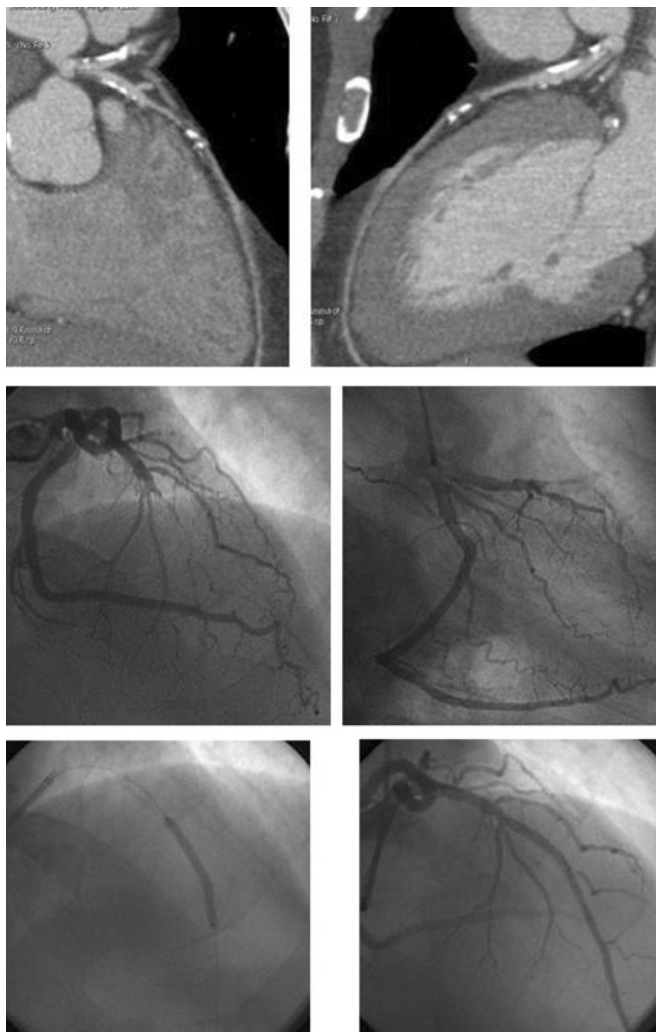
Critical LAD stenosis according to CTA interpretation (upper panel) revealed as total LAD occlusion using “invasive” angiography (middle panel) and undergoing successful stent-based PCI procedure (lower panel).
